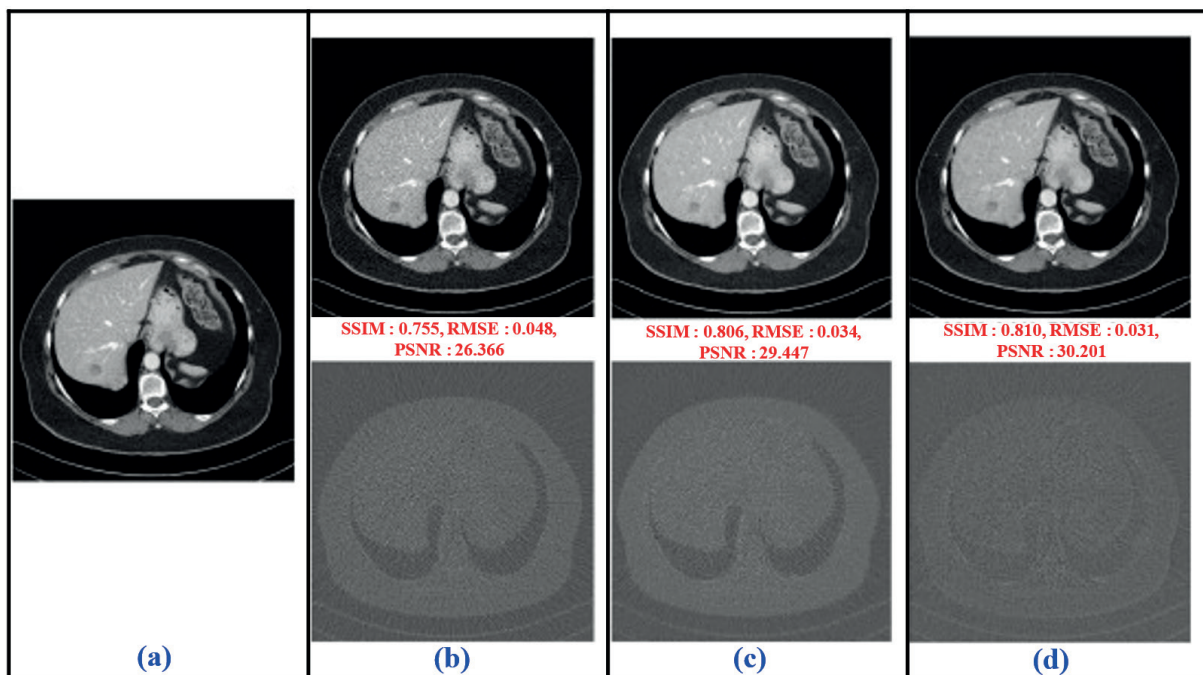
Utilizing computed tomography at the maximum effective dosage (a) The recommended dose of CT is 25 mg (optional clause). (b) The initial version of the WGAN-VGG (c) proposed model-WGAN-VGG (d) Proposed Model. The range of values that can be displayed on the CT screen is between 160 and 240 HU
